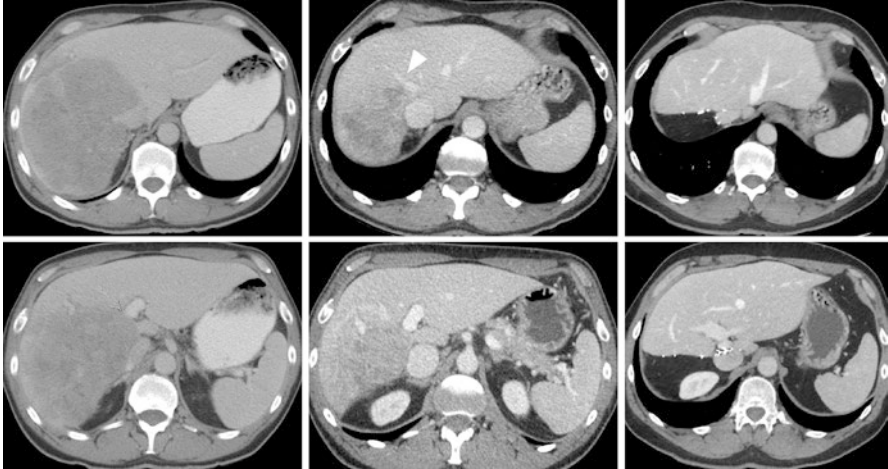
Locally advanced intrahepatic cholangiocarcinoma managed with neoadjuvant chemotherapy and surgical resection: Fifty-one year old man who presented with abdominal pain and weight loss. Computed tomography (CT) at presentation (left column) showed a large liver tumor encasing the retrohepatic IVC and right hepatic vein origin (top left image), in addition to abutting the left portal vein (bottom left image, green arrow). There was no evidence of portal lymphadenopathy or distant metastatic disease. Given the borderline resectable nature of the tumor, 4 months of gemcitabine-cisplatin chemotherapy were administered. CT images (middle column) after neoadjuvant chemotherapy and before resection show significant response in terms of size with persistent vascular abutment (top middle image: white arrow, middle hepatic vein). The patient underwent an extended right hepatectomy and portal lymphadenectomy. No IVC or portal vein resection was required intraoperatively. The tumor was 90% viable, and there was carcinoma within 1 mm of the surgical margin. All 7 portal lymph nodes were negative. The tumor was unifocal. The patient received 2 more months of adjuvant gemcitabine-cisplatin chemotherapy and is alive with no evidence of disease 4 years postoperatively (right column)
